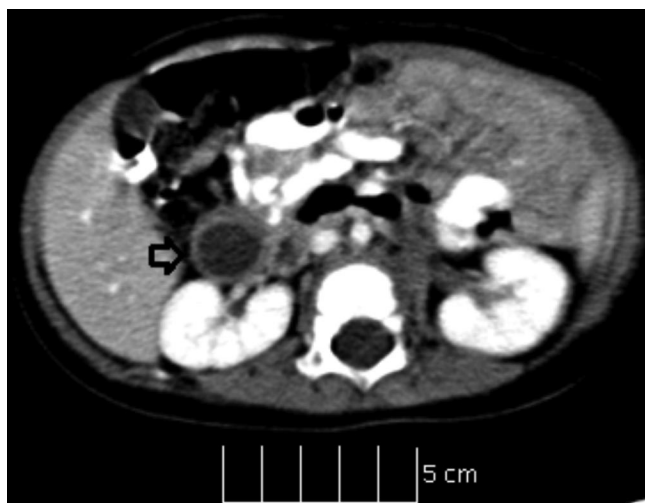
Computerized tomography (CT Scan) of the abdomen revealed a 1.9cm x 1.2cm diameter thin-walled cystic structure (arrow).
